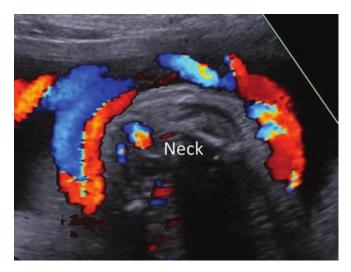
Nuchal cord incidentally noted with color Doppler in a transverse image of the fetal neck at 34 weeks' gestation.
